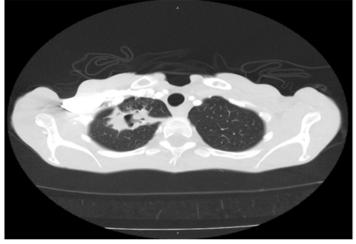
CT chest: Cavitary changes
